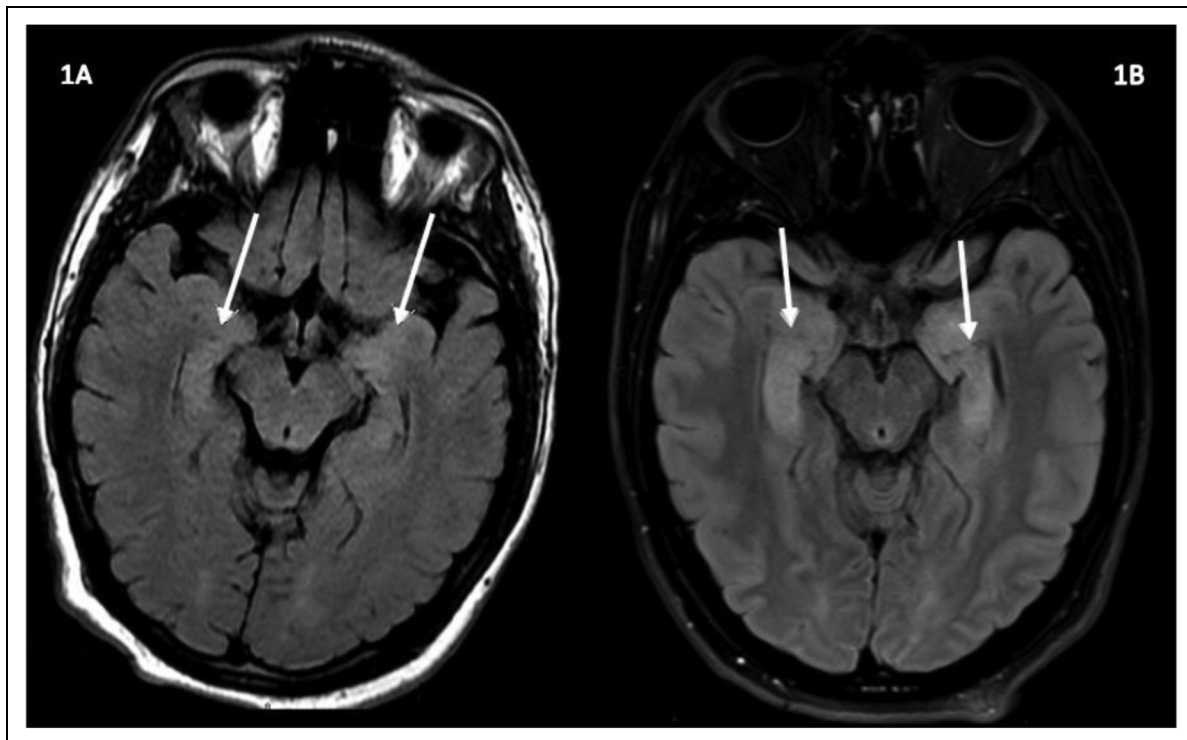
A: Axial T2 FLAIR from HD2. Increased FLAIR signal abnormality within the left greater than right temporal lobe. In the left temporal region abnormal signal extends into the left parahippocampal gyrus and medial aspect of the left thalamus. Areas of abnormal signal indicated with arrows. B (Right): Axial T2 FLAIR from HD5. Mildly increased (compared to HD2) signal involving left greater than right medial temporal lobes and hippocampus bilaterally with areas of cytotoxic edema in the hippocampi. Areas of abnormal signal indicated with arrows.
